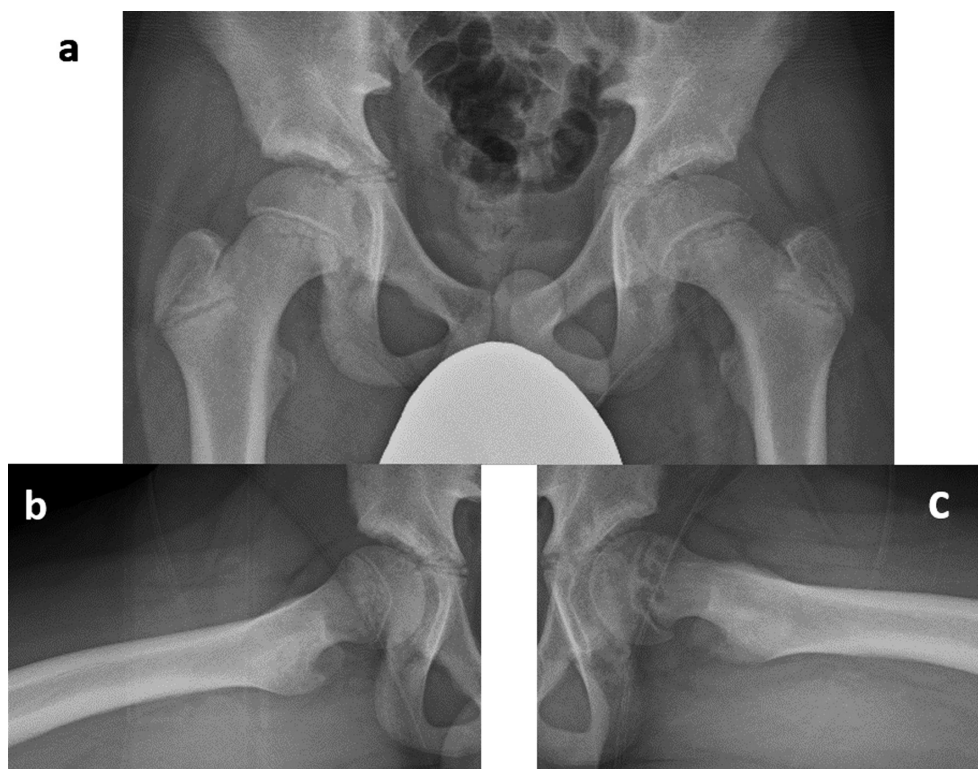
Radiographs of the patient at the time of presentation with left slipped capital femoral epiphysis. a: Anteroposterior view, b: right lateral view (PSA: 11°), c: Left lateral view (PSA: 15°). PSA: posterior sloping angle.
